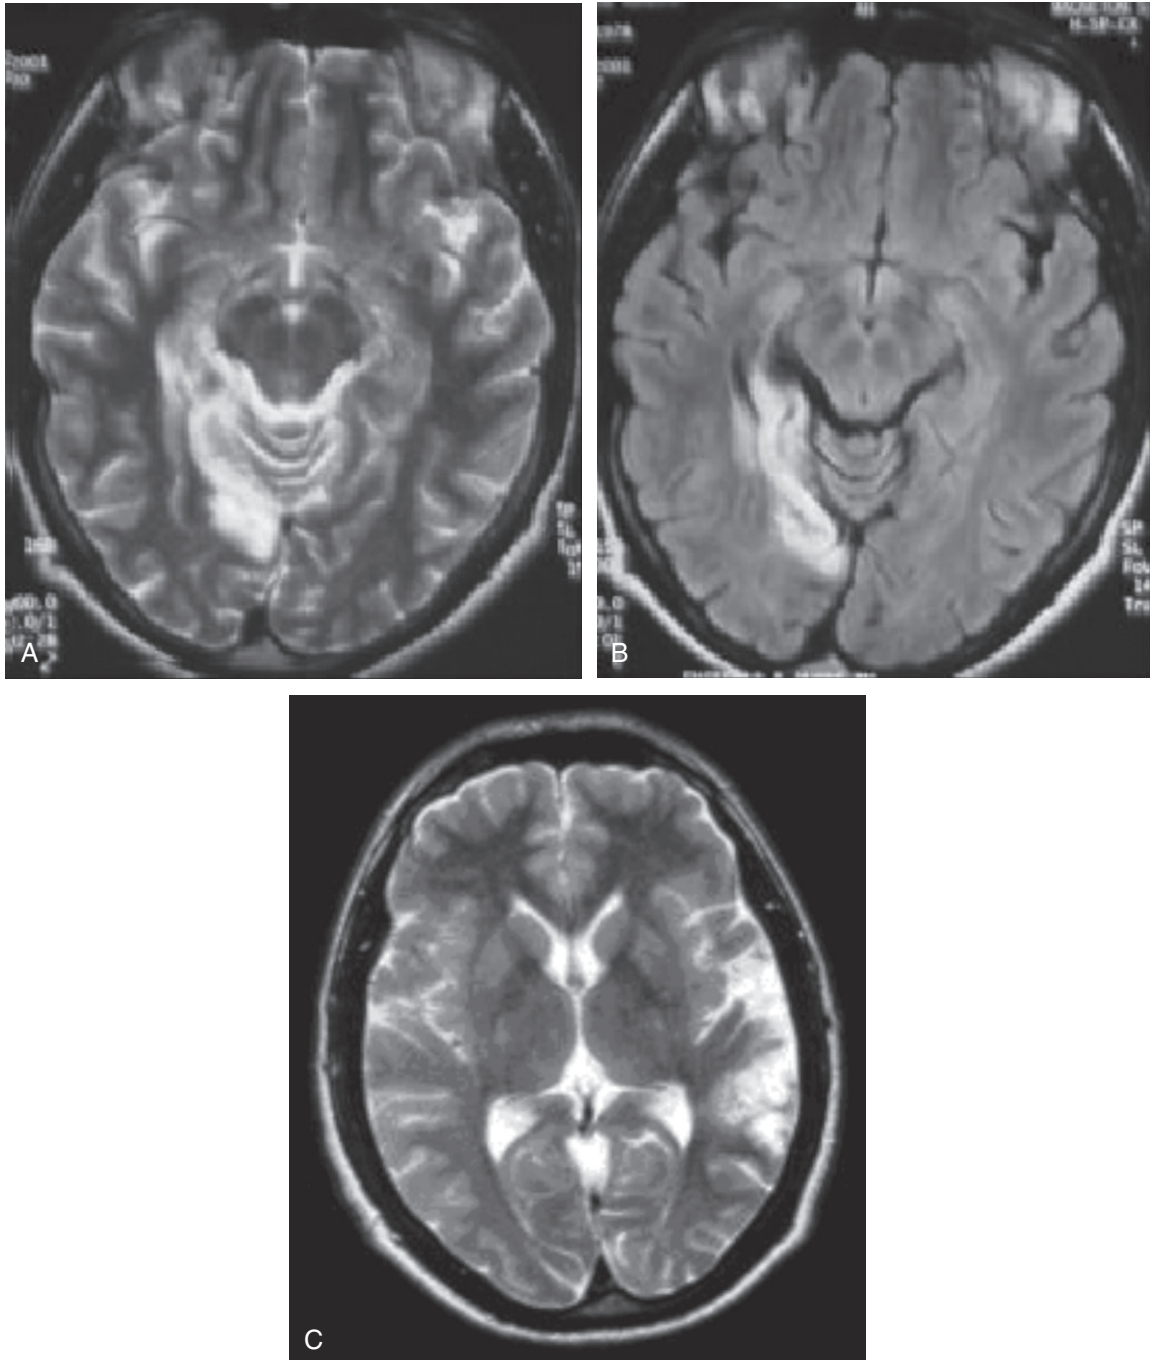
(A and B) Brain magnetic resonance imaging (MRI) showing an area of increased signal on T₂-weighted and fluid-attenuated inversion recovery (FLAIR) sequences indicating ischemic stroke in the right posterior cerebral artery (PCA) territory involving the calcarine branches. (Courtesy of Professor Stefano Bastianello.) (C) Brain MRI showing a cortical area of increased signal on T₂-weighted sequences indicating chronic cerebral ischemia in the left middle cerebral artery territory, involving the insular and posterior temporal branches. (Courtesy of Professor Stefano Bastianello.)
